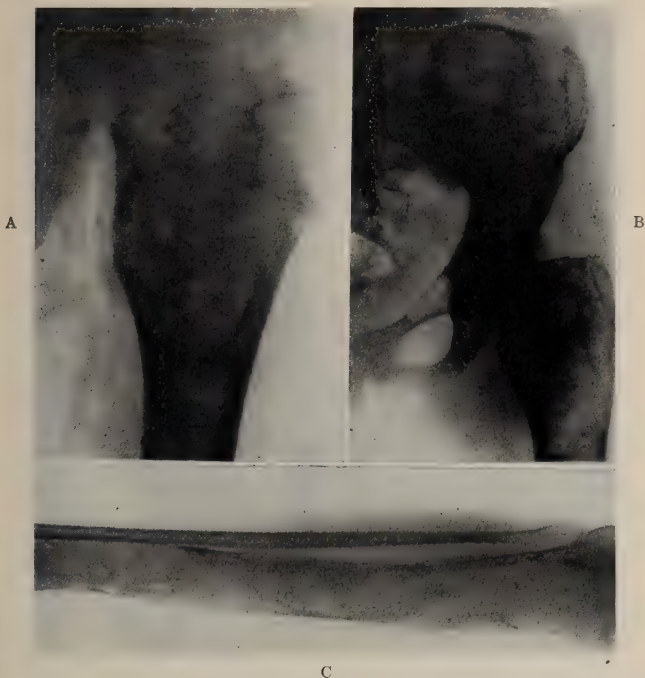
A, Roentgenogram of a focus of fibrous dysplasia in the neck and adjacent portion of the shaft of a femur from a girl of 12. This was the only lesion present in this case.
